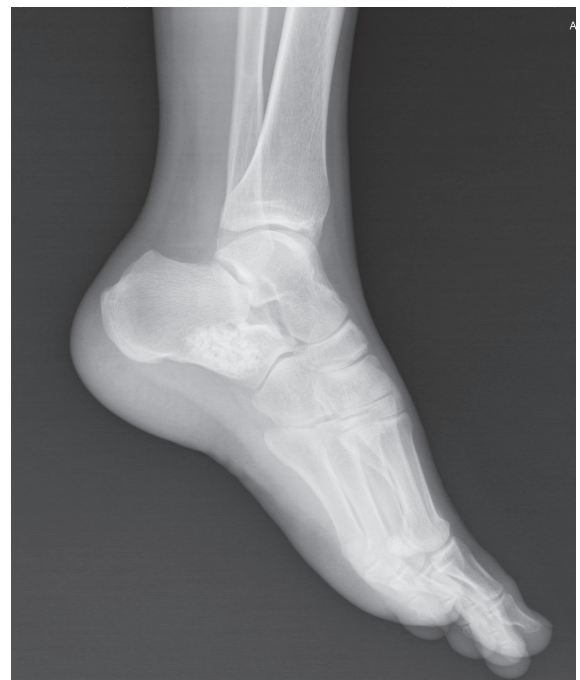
Lateral postoperative X-ray of a calcaneal lipoma
